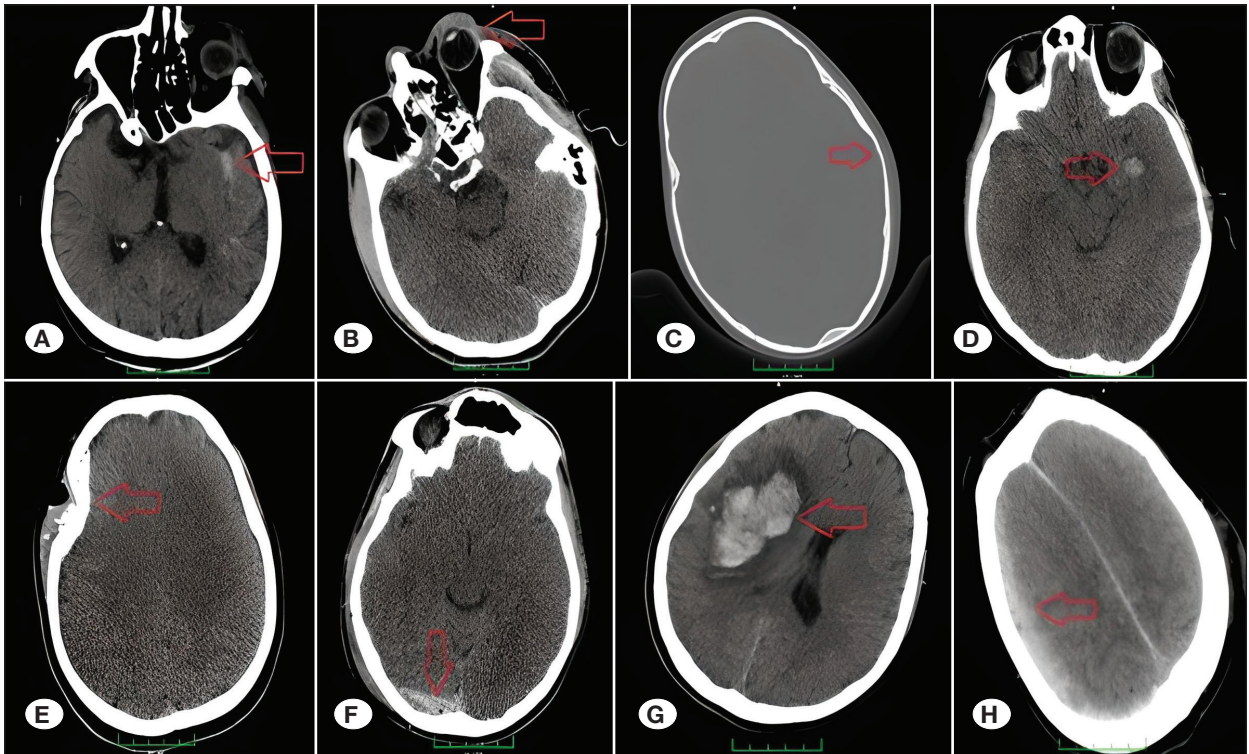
Axial section brain CT scan showing evidence of head trauma.
